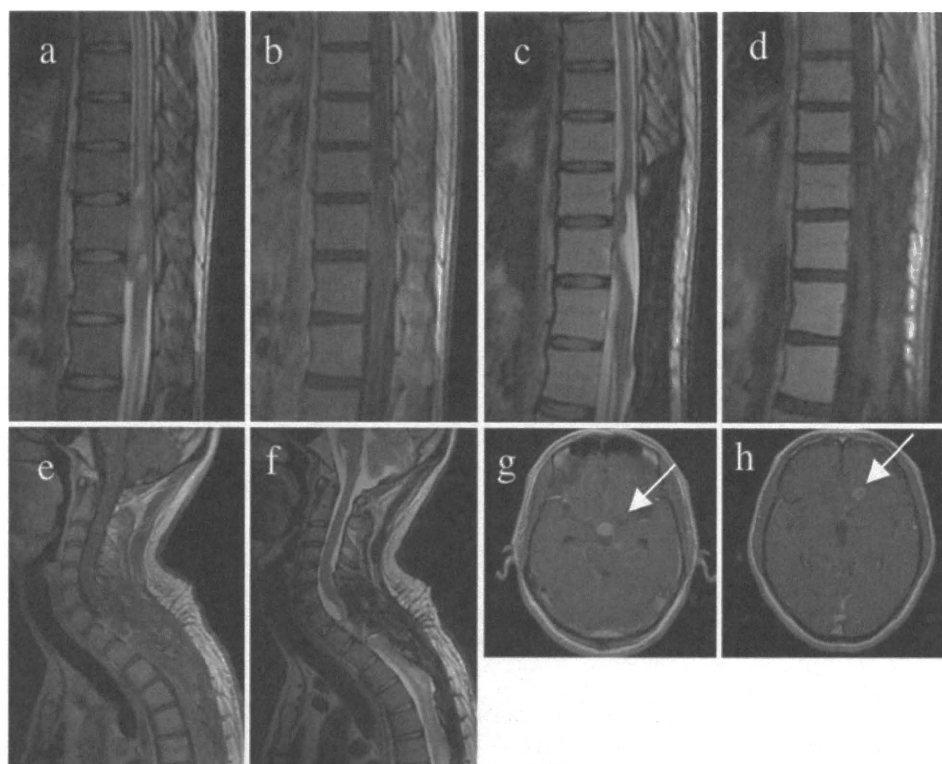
Case 6. Preoperative T2-weighted (a) and Gd-enhanced T1-weighted (b) MR images showing T2 high signal and heterogeneously Gd-enhanced tumor at the T10–12 levels. Sagittal T2-weighted (c) and Gd-enhanced T1-weighted (d) MR images obtained after primary surgery, demonstrating no residual tumor. Sagittal Gd-enhanced T1-weighted (e) and T2-weighted (f) MR images obtained after cordotomy at C7–T1, showing no tumor cells at the stump of the cordotomy. Axial Gd-enhanced T1-weighted MR images (g and h) obtained 1 year after cordotomy, revealing CSF dissemination (arrows).
